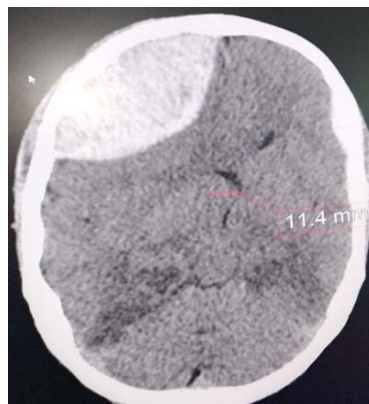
Brain CT without contrast product injection, axial section in parenchymal window: right frontal extradural hematoma.
